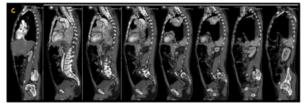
CT section showing defect in left diaphragm.
